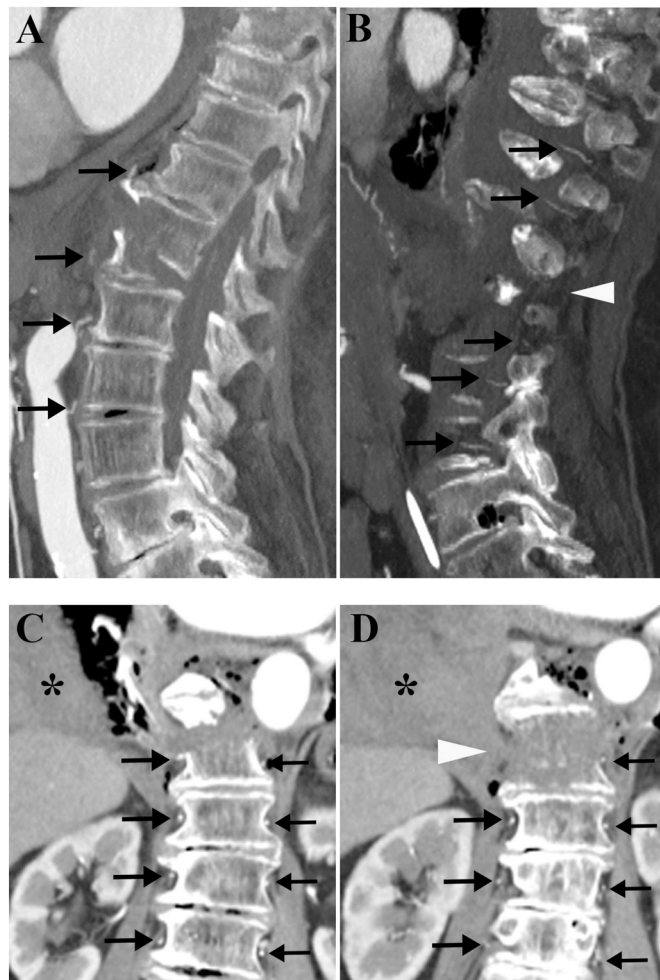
Enhanced sagittal (A and B) and coronal (C and D) CT images. Enhanced arteries are identified by arrows, and arteries that are not enhanced are identified by arrowheads. Asterisks show right hemothorax (C and D).
